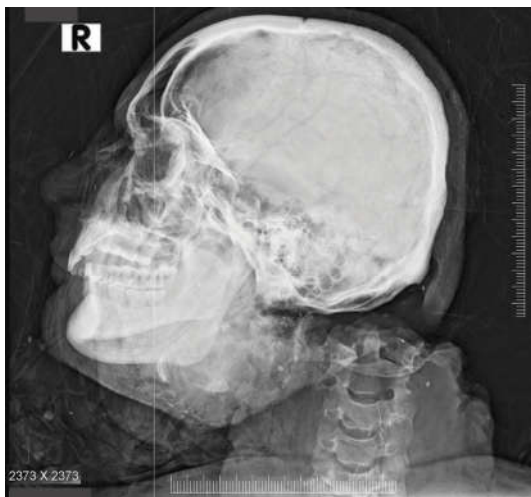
Digital X-ray of head and neck.
